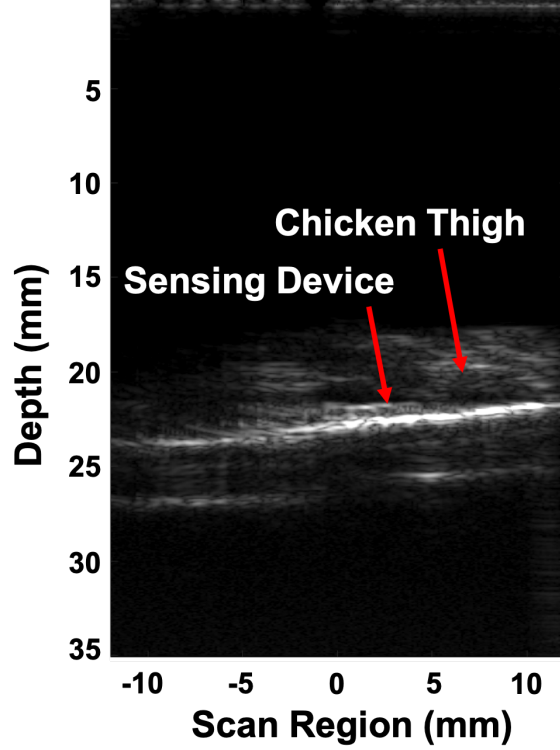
The ultrasound image showing a piece of chicken thigh placed on top of a sensing mote during a fully-wireless testing.
